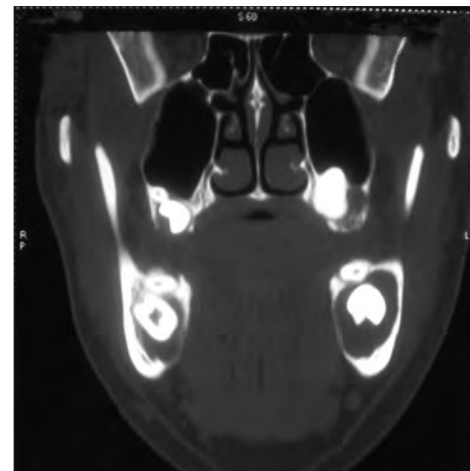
The coronal view of mandible in CT image shows bilateral lingual bone perforation
